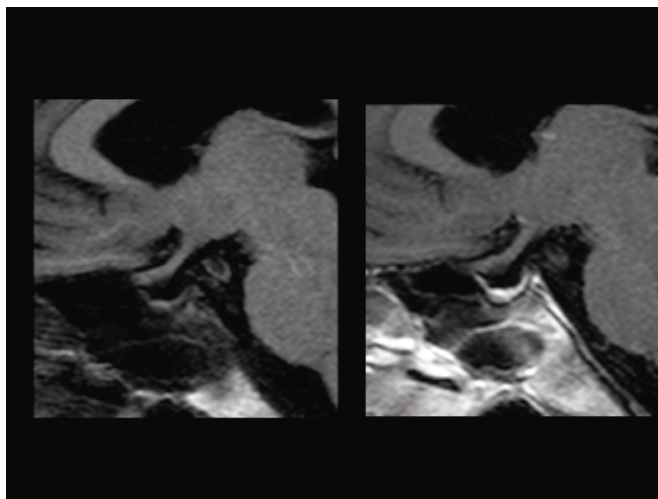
The patient's head magnetic resonance image (MRI). The head MRI shows an empty sella (left: plain, right: enhanced).
